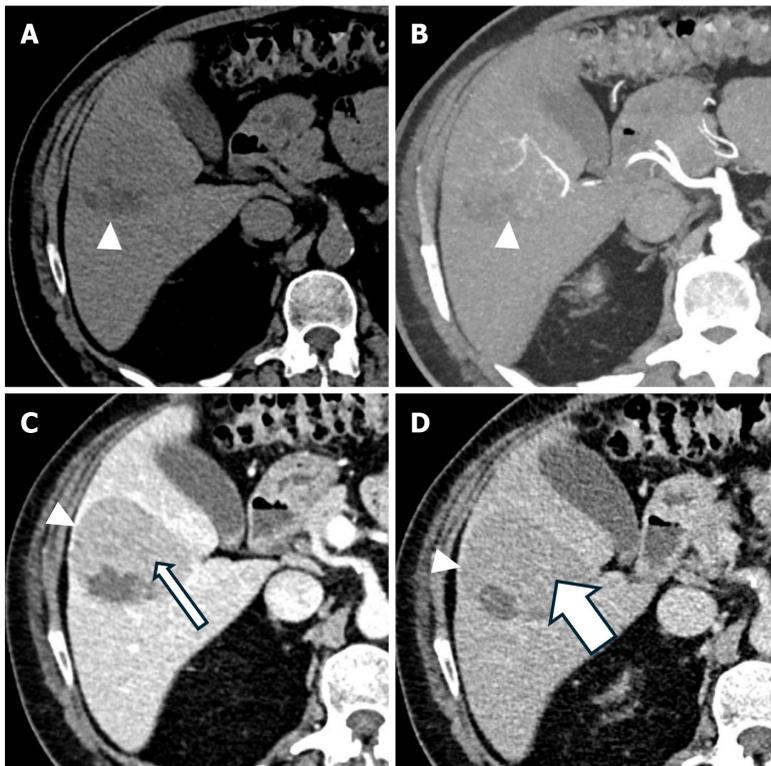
Hepatocellular carcinoma in a 58-year-old man with chronic hepatitis B infection. A: Axial non-contrast computed tomography (CT) image shows the hypodense lesion(arrowhead); B: Axial contrast-enhanced CT image in the arterial phase shows an enhancing lesion (arrowhead); C: Axial contrast-enhanced CT image in the portal venous phase shows the lesion(arrowhead) with a washout (thin arrow); D: Axial contrast-enhanced CT image in the delayed phase shows the lesion(arrowhead) with further washout (thick arrow).
